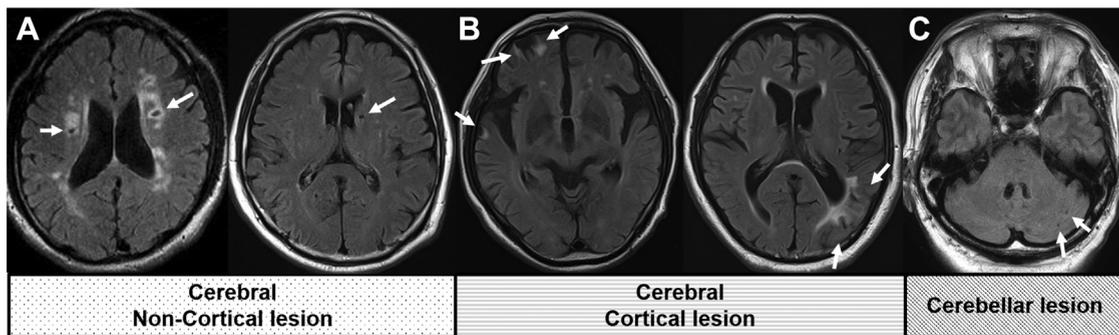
Classification of silent cerebral infarctions according to location on brain magnetic resonance imaging. A: Cerebral noncortical infarcts, defined as focal, sharply demarcated noncortical lesions in the cerebral white matter or deep gray matter. B: Cerebral cortical infarcts, defined as cortical lesions corresponding to the territories of large cerebral arteries. C: Cerebellar infarcts.
